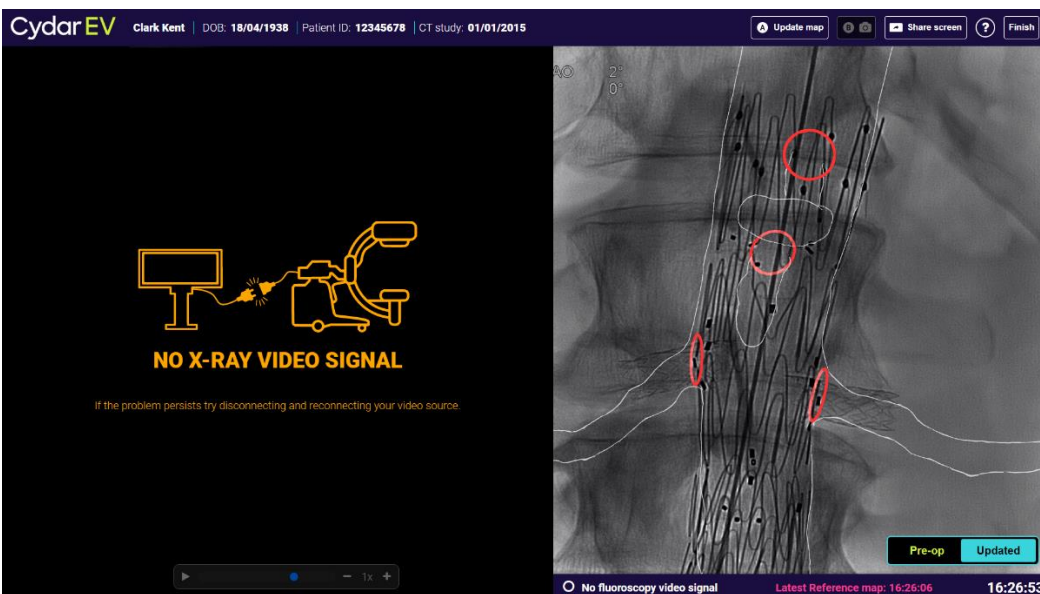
The message on the left indicates that the Cydar Appliance is not receiving a video signal from the X-ray set. Check the Xray set is powered on, the DVI cable is connected, and any signal converters are powered on. If problem persists, contact Cydar Online Support.
